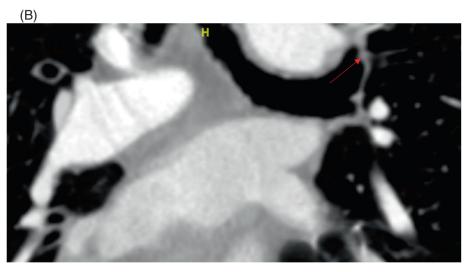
(A) An enlarged submucosal vessel in the inferior wall of the left upper lobe bronchus. (B) Coronal sections of CT thorax show an enlarged submucosal vessel (red arrow) in the left secondary carina at the origin of left upper lobe. CT, computed tomography.
